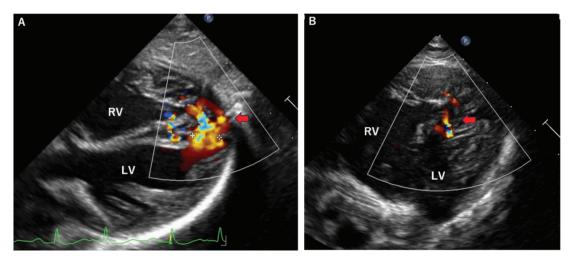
Pre (A) and post (B) operative echocardiographic image. The width of apical VSDs shunt flow (red arrow) was decreased postoperatively
